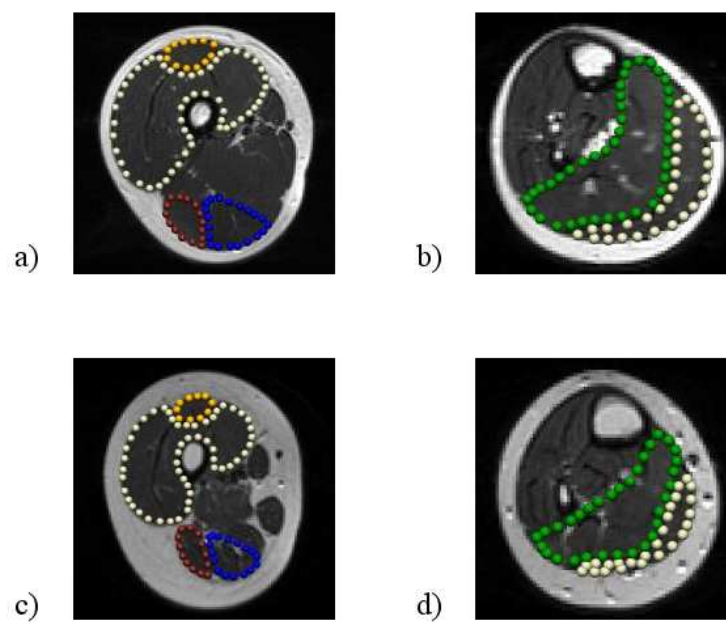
MRI slices of a) the thigh and b) the shank in a typically developing child (subject 005, Table 4.1), and b) the thigh and c) the shank in a child with hemiplegic CP (subject 004, Table 4.2). The muscles are coloured as follows: rectus femoris in gold, vasti in silver, biceps femoris in red, semimembranosus in blue, soleus in green and gastrocnemius in white.
